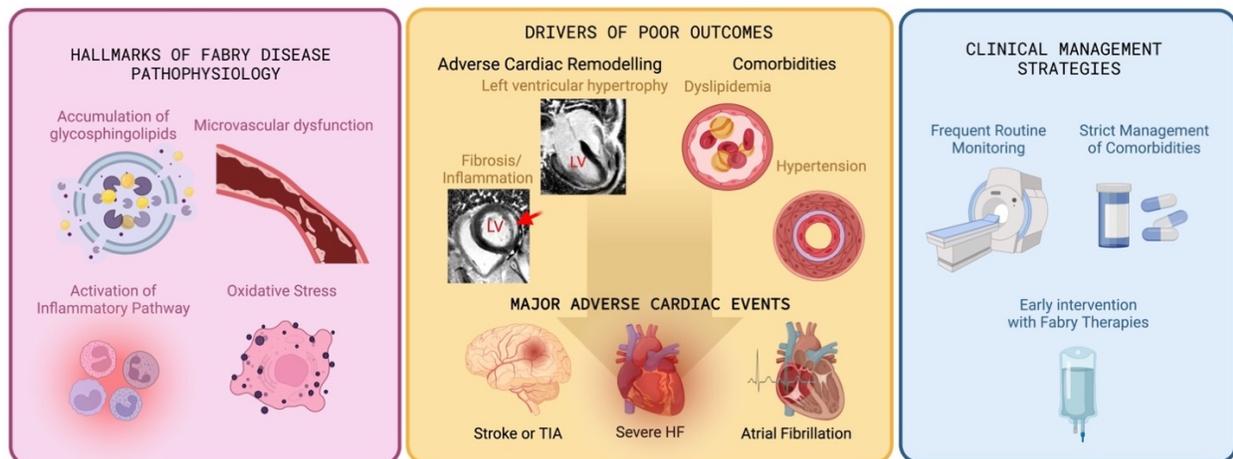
The combined pathological effects of the hallmarks of Fabry disease pathology lead to changes in heart morphology and function that can be detected by cardiac magnetic resonance imaging. Presence of markers of cardiac remodelling and comorbidities predict major adverse cardiac events. Frequent monitoring and management of risk factors and early intervention with Fabry-specific therapies attenuate disease progression and prevent poor outcomes.
